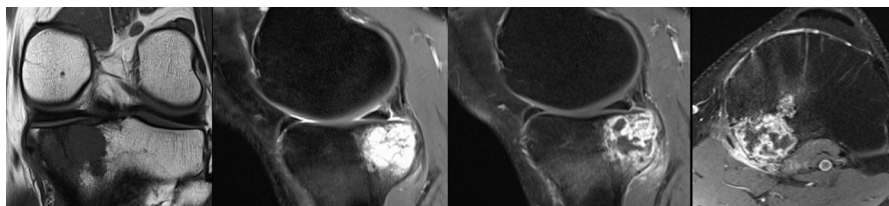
Male, 31 years: Chondrosarcoma grade II. MRI performed for suspected meniscal lesion after distortion of the knee joint. The pattern is consistent with a ring-and-arc chondroid matrix. However, it exhibits aggressive features such as endosteal scalloping and soft tissue extension. Furthermore, the intraepiphyseal location must raise suspicion for an atypical process.
